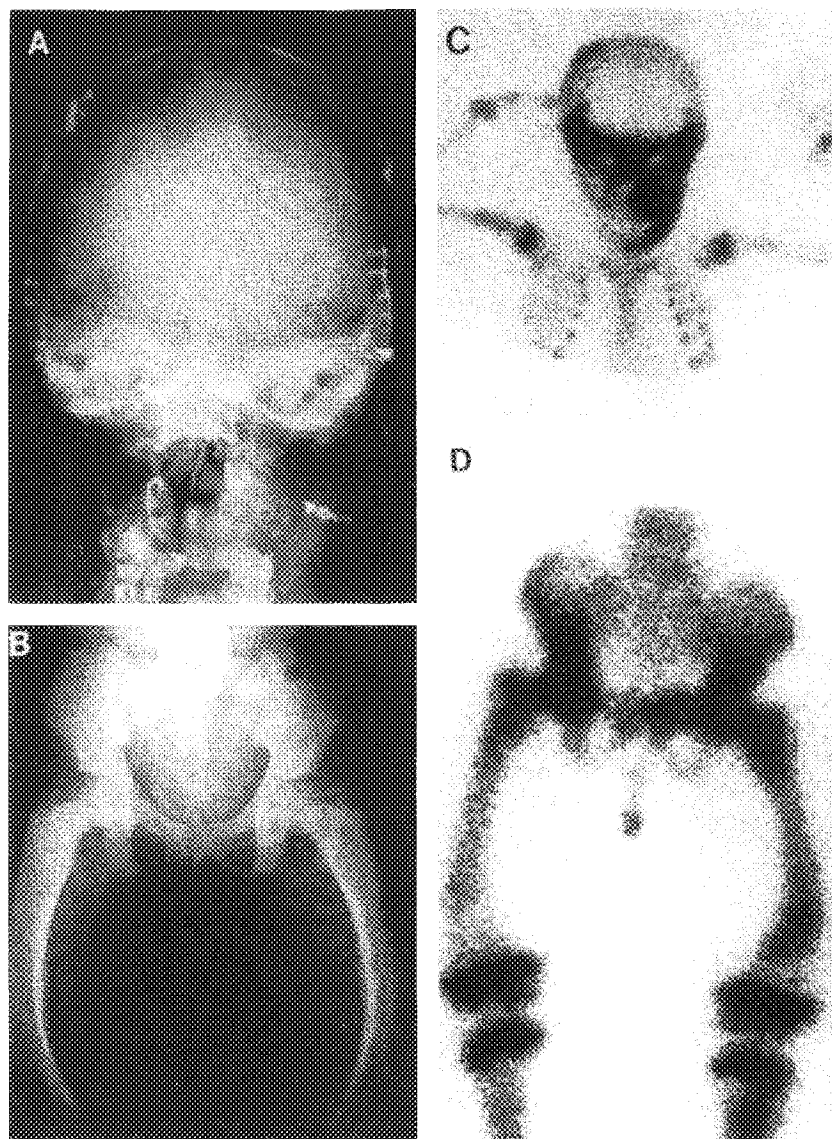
Widespread fibrous dysplasia as seen on skull (A) and femoral (B) radiographs and corresponding bone scans (C and D). (From Pfeffer *et al.* [31]; with permission.)
